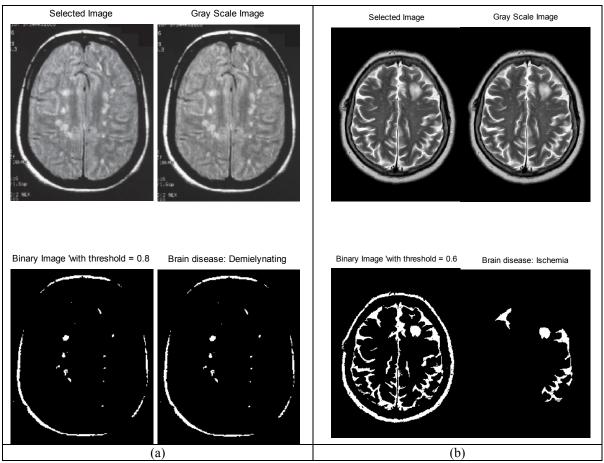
MRI images after the processing and detection of features for identify (a) Demyelinating brain disease (BI) and (b) Ischemia brain disease (BD).
